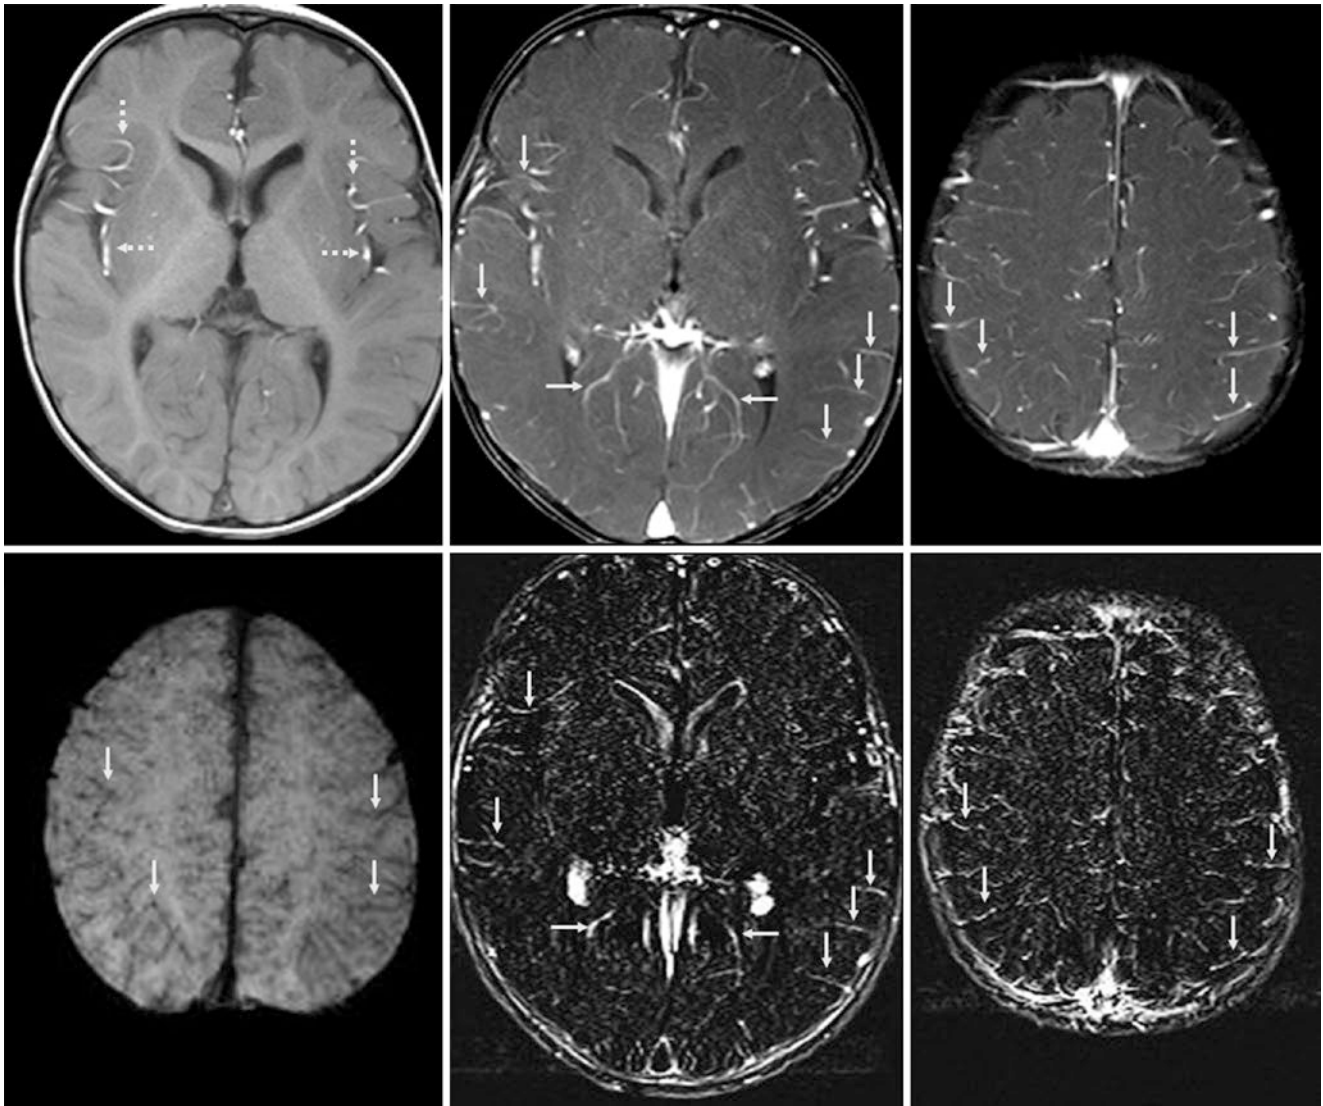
A 1 year old had a questionable history of a remote neonatal infection and lacked acute symptoms. A negative 3T MRI with IV sedation showed normal vascularity (*dotted arrows*) on noncontrast GET1WI (*top left*) with mild pseudo-LMCE (*arrows*) on CEMRI
